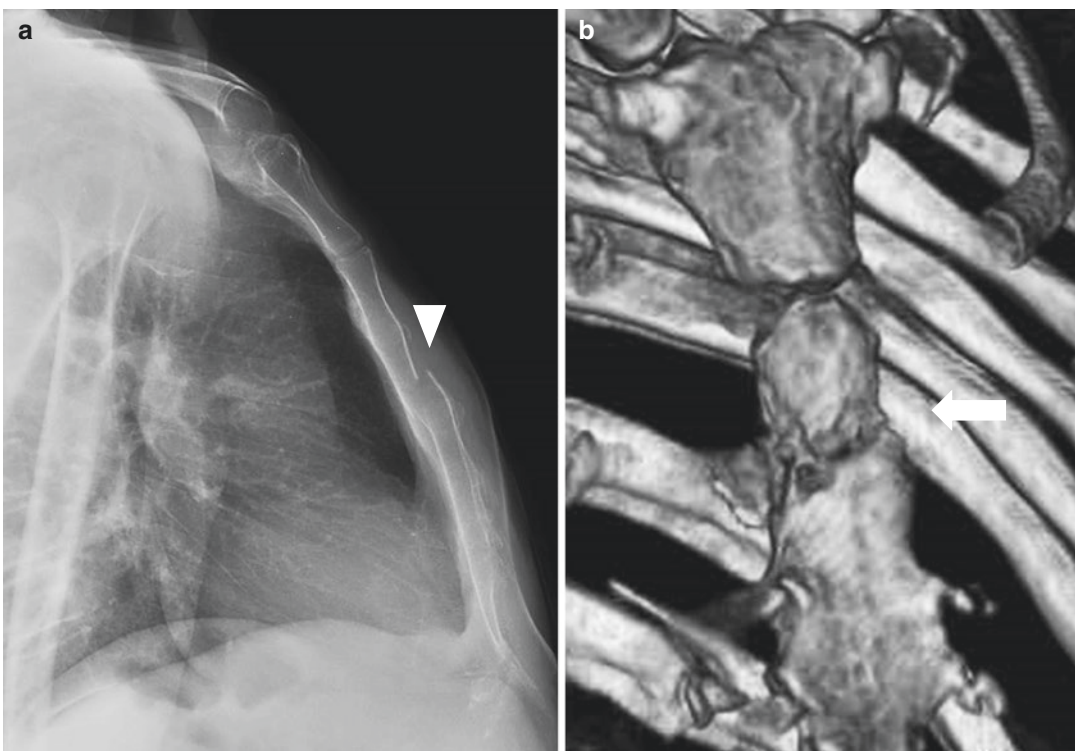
Lateral X-ray projection of the sternum (a) showing a fracture in the upper third of its body (arrowhead) confirmed in 3D reconstruction of MDCT (b) (arrow)
